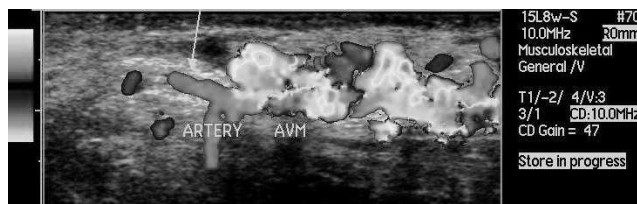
Ultrasound scan showing arteriovenous fistula on the radial aspect of the left third metacarpophalangeal joint. Multiple dilated veins demonstrate arterialized waveforms within the dorsal aspect of the left hand overlying the second and third metacarpal head region.
